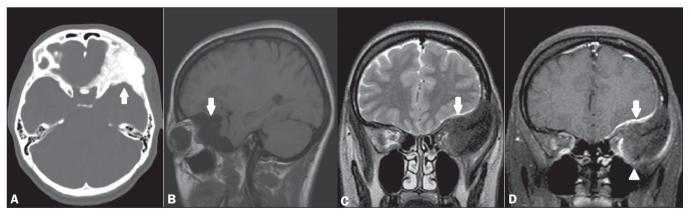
A: Axial CT scan, with bone window settings, showing an expansile, osteoblastic lesion, affecting the upper/lateral wall of the left orbit (arrow). B: Noncontrast sagittal T1-weighted MRI sequence, showing a lesion with a hypointense signal (arrow). C: Coronal T2-weighted MRI sequence, also showing the lesion with a hypointense signal (arrow). Also note the compressive effect and displacement of the intraorbital structures, including the optic nerve. D: Contrast-enhanced coronal T1-weighted MRI sequence, showing a lack of significant contrast uptake within the lesion (arrowhead), with only slight uptake in the dura mater subjacent to the tumor (arrow).
